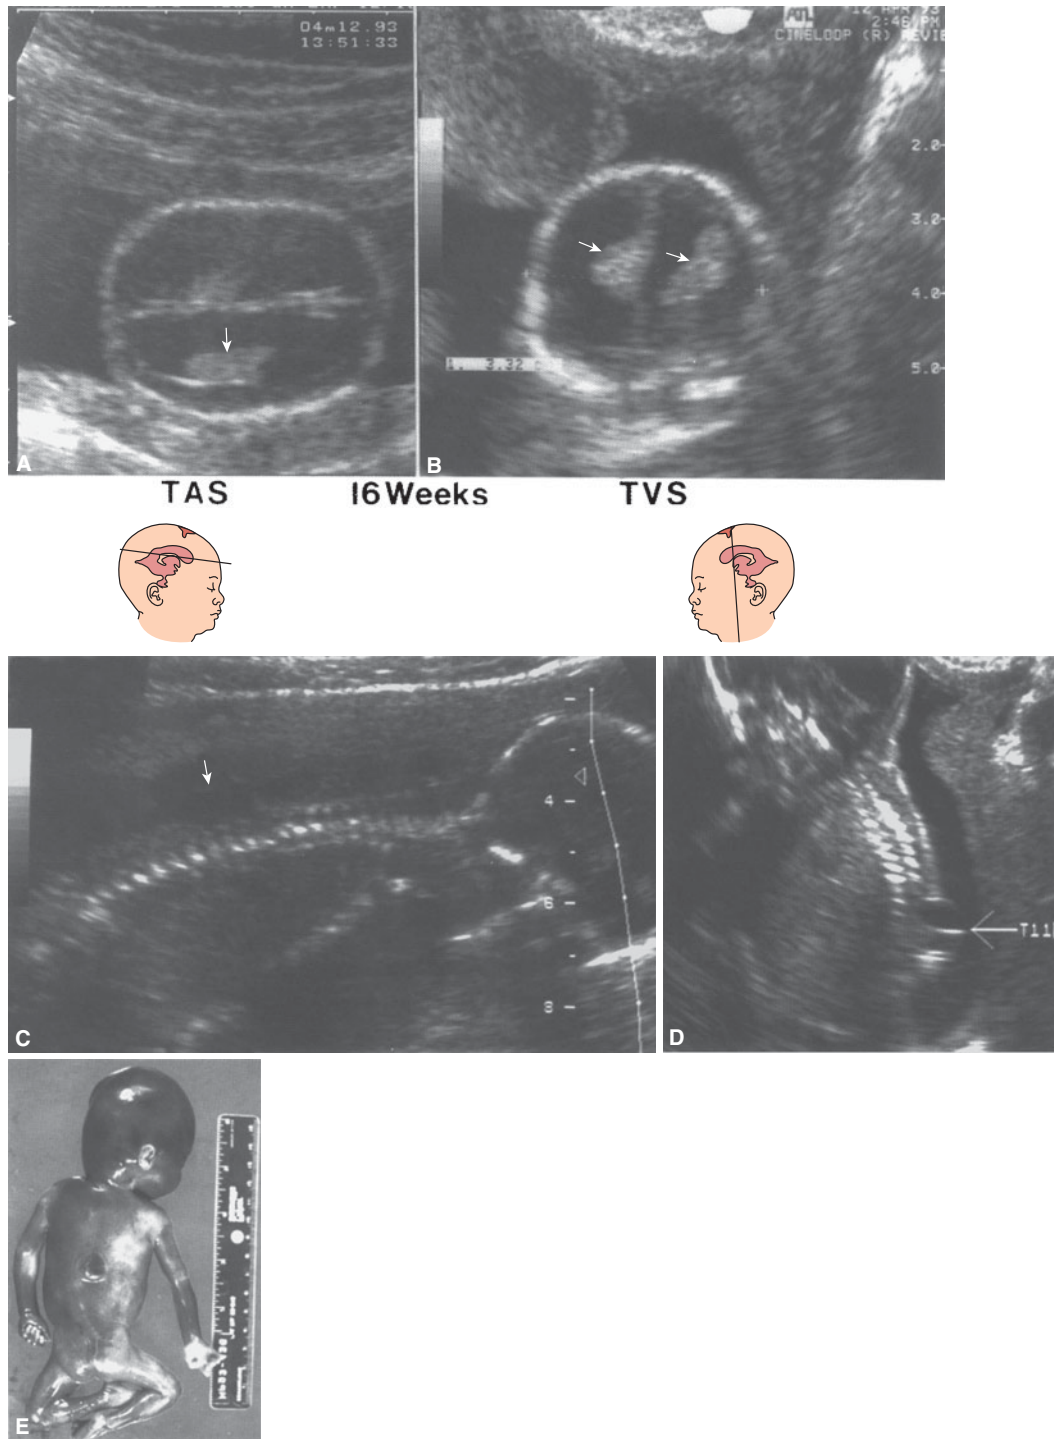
Arnold-Chiari type II malformation diagnosed at 16 postmenstrual weeks by transabdominal and transvaginal sonography. Diagnosis: thoracic spina bifida. (A) Horizontal transabdominal section of brain demonstrating the dilated lateral ventricles and the dangling choroid plexus (arrow). (B) Transvaginal scan using the mcoronal-1 section showing the dangling choroid plexus within the dilated ventricles (arrow). (C) The transabdominal scan with a 3.5 MHz probe demonstrates the faint outlines of the meningocele (arrow). (D) The transvaginal picture was created by a 5MHz probe, which easily images the lesion at the 11th thoracic vertebra (arrow). (E) The aborted fetus with the lesion of the thoracic meningocele and spina bifida.
